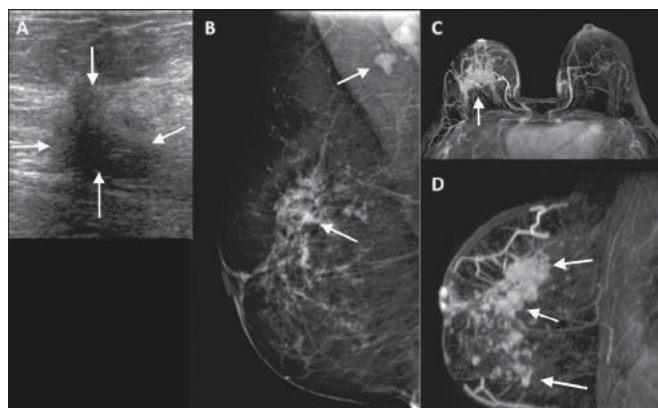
Breast Ultrasound (A), FFD Mammogram (B) and Breast MRI (C and D): The images show a less common type of breast cancer, an invasive lobular cancer; this type of cancer is poorly seen on FFD mammograms (B) but is detected by breast ultrasound (A). However, its full extent can only be seen on Breast MRI (C and D); it involves the whole right breast (arrows). Breast MRI is the only test that accurately assesses the extent of lobular breast cancer.
